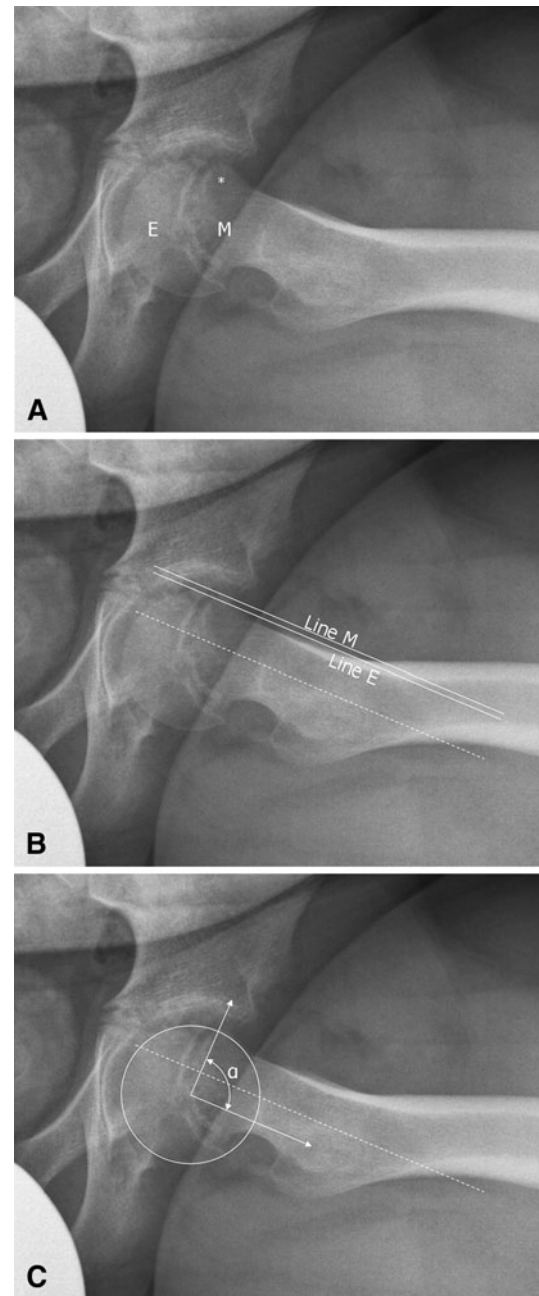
Frog-leg lateral radiographs of the hip show posterior tilt and translation of the epiphysis (E) with anterior prominence (*) of the proximal metaphysis (M). (A) Left hip of Patient 2. (B) Epiphyseal-metaphyseal offset of left hip of Patient 2. (C) Alpha angle of left hip of Patient 2. Dashed line = line along center of femoral neck; Line E = line along anterior epiphysis parallel to femoral neck; Line M = line along anterior metaphysis parallel to femoral neck; α = alpha angle.
